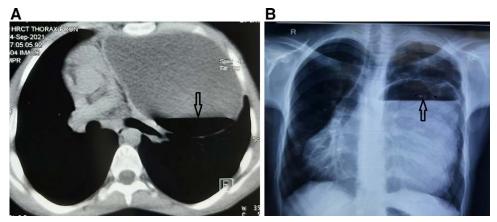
Chest imaging. A, High-resolution computed tomography of the thorax. A large bronchogenic cyst occupying the left hemithorax, pushing mediastinal structures to the right. The air-fluid level inside the cyst cavity (downward arrow) is inverted, as the CT scan was taken with the patient in a prone position. B, Chest radiograph (posteroanterior view) of the patient in the upright position. A horizontal air-fluid level (upright arrow) can be seen inside the cyst cavity.
